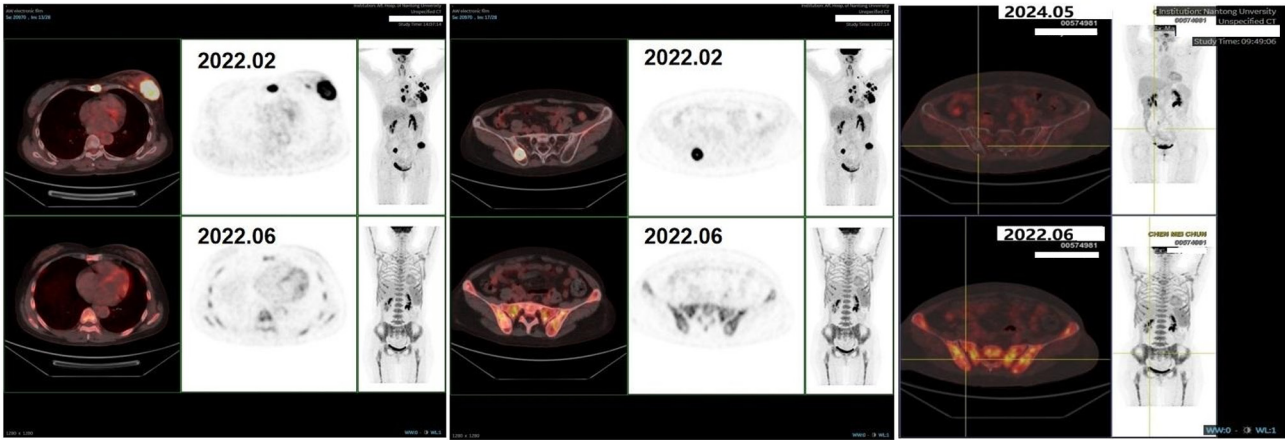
Positron emission tomography-computed tomography images before and after treatment.
